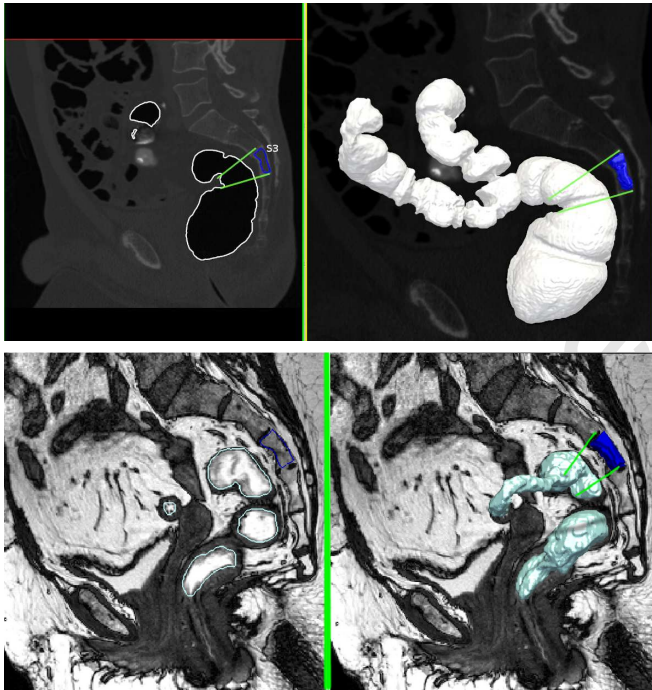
Anatomical Marker Validation Scheme in CTC and MRI images. S3 limits are projected over the digestive tube to determine a valid limit interval. On the left of each modality, a 2D slide projection of the S3 limits over the digestive tube border. The right sides show the corresponding 3D visualization.
